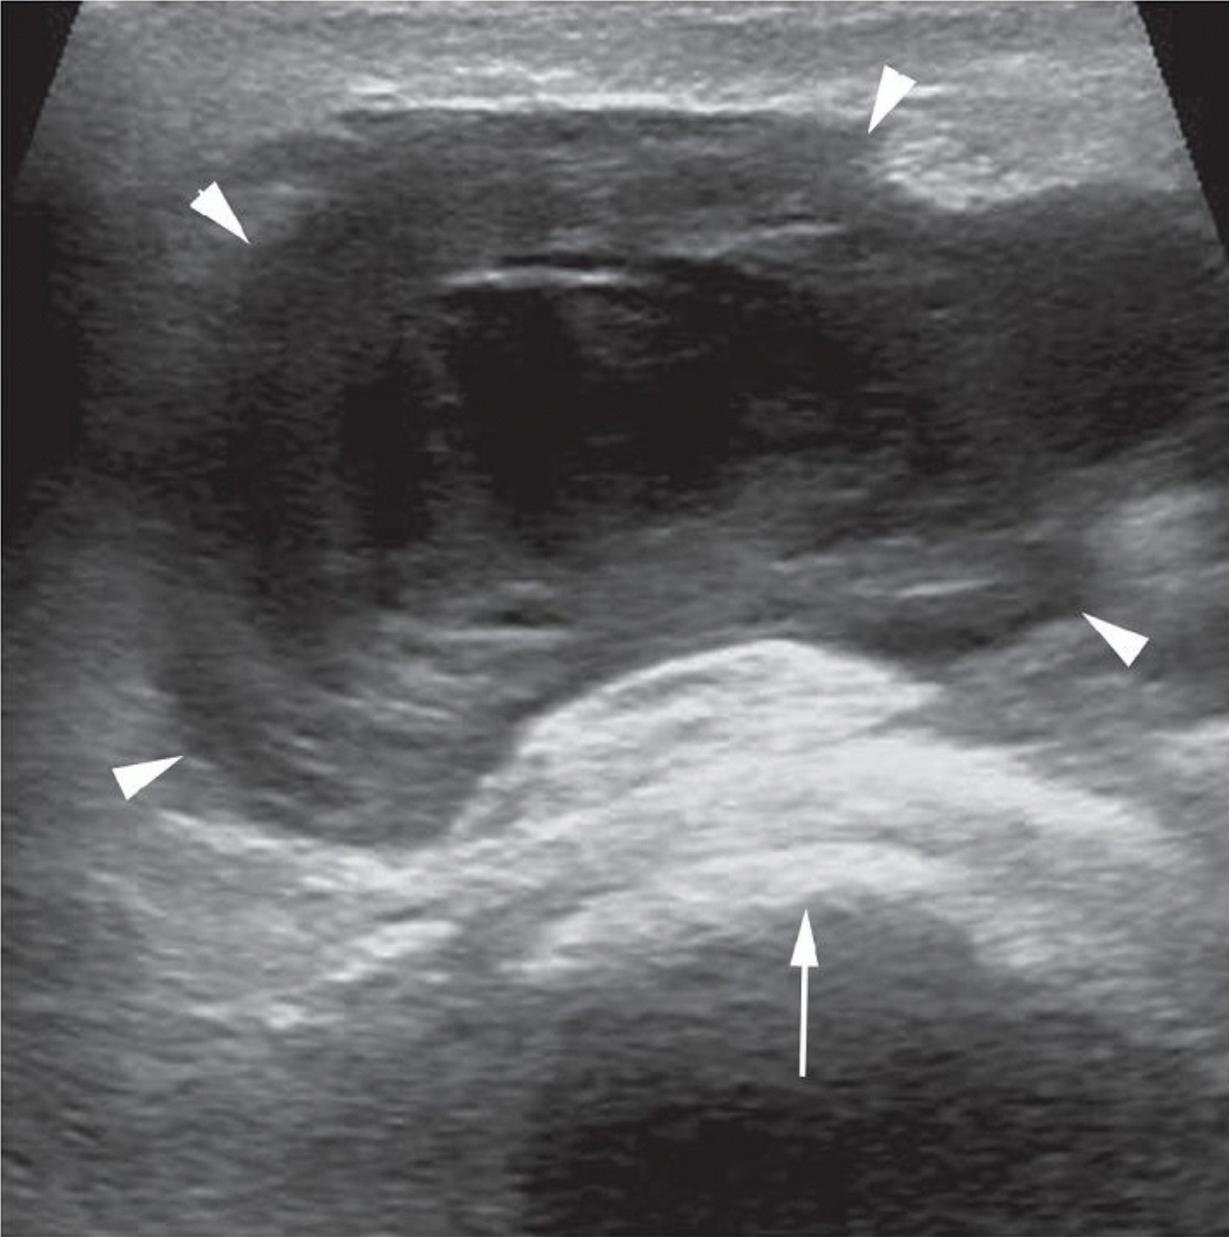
Organizing hematoma following THR surgery. Transverse sonogram shows organizing hematoma (arrowheads) with complex internal structure and underlying hyperechoic prosthesis (arrow).
